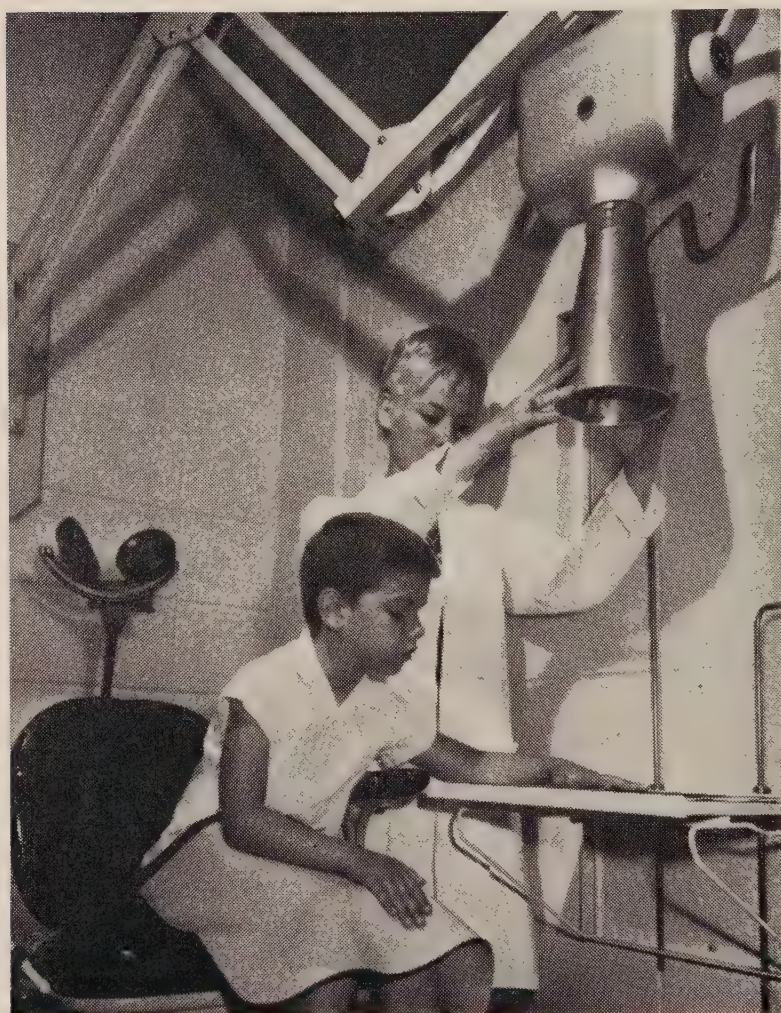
Prise de la radiographie de la main et du poignet.
